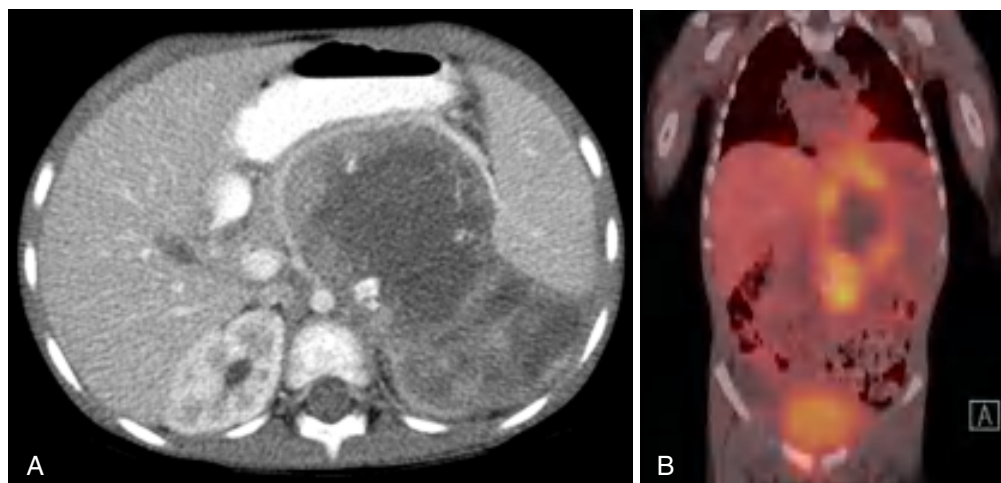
A, CT scan of an abdominal neuroblastoma with central necrosis at diagnosis. B, Coronal fused CT and metaiodobenzylguanidine (MIBG) image of the same child with extensive retroperitoneal mass and central necrosis, probably an adrenal primary with extensive lymph node involvement. C, MIBG avid neuroblastoma with increased uptake of radiolabeled tracer can be detected in multiple sites of disease, including bone and soft tissue.
